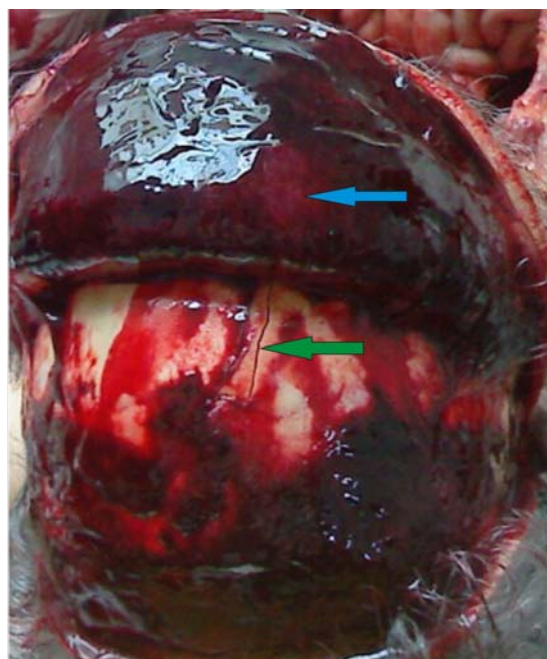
(b): Diffuse scalp extravasation (blue arrow) over fronto parietal region with fissured fracture (black arrow), which was not reported in CT scan.
